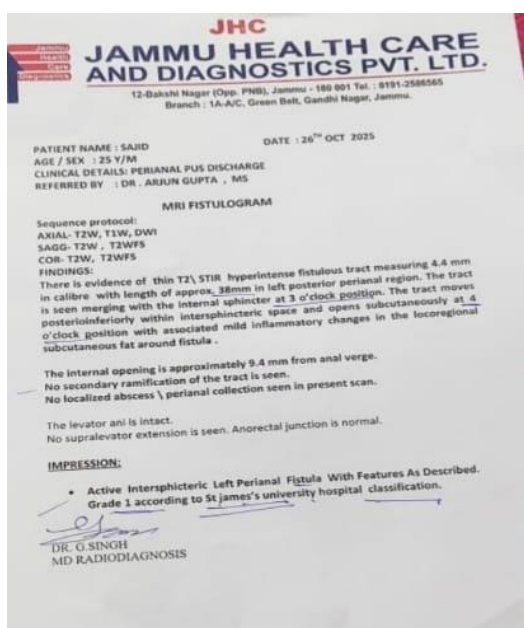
(a) MRI fistulogram report confirming an active intersphincteric left perianal fistula, Grade 1 (St James's classification); (b) OPD case sheet at initial presentation.
